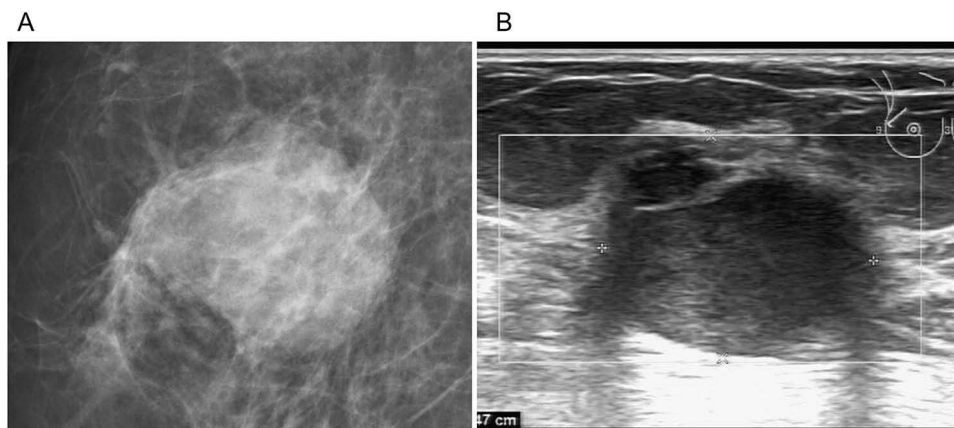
Image of a 72-year-old female patient. (A) The X-ray shows a high-density oval mass in the upper outer quadrant of the right breast with infiltrative margins and no burr sign. (B) The ultrasound shows a hypoechoic mass with uneven internal echoes and slightly reduced posterior echoes. The pathologic diagnosis was a non-specific invasive ductal carcinoma of the right breast (grade II), 2.8 cm×2.5 cm×2 cm in size.
